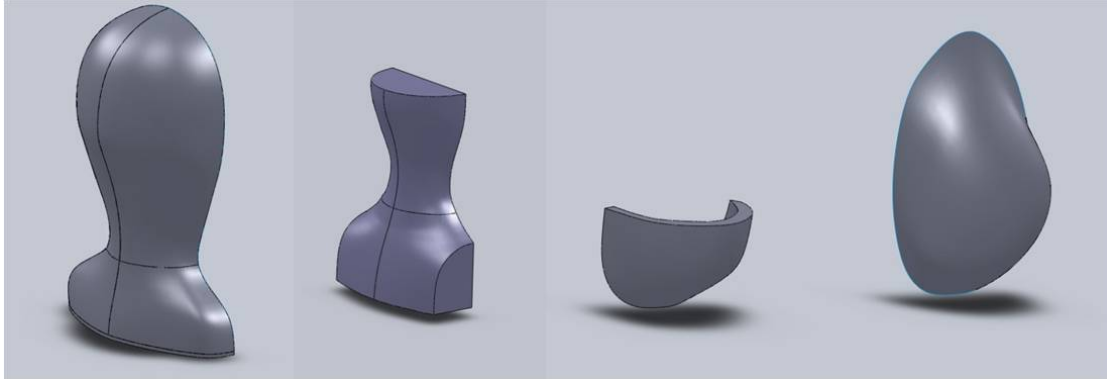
Examples of anatomical 3D mold models for the head, neck, and breast. Molds were created from high resolution MRI data.
